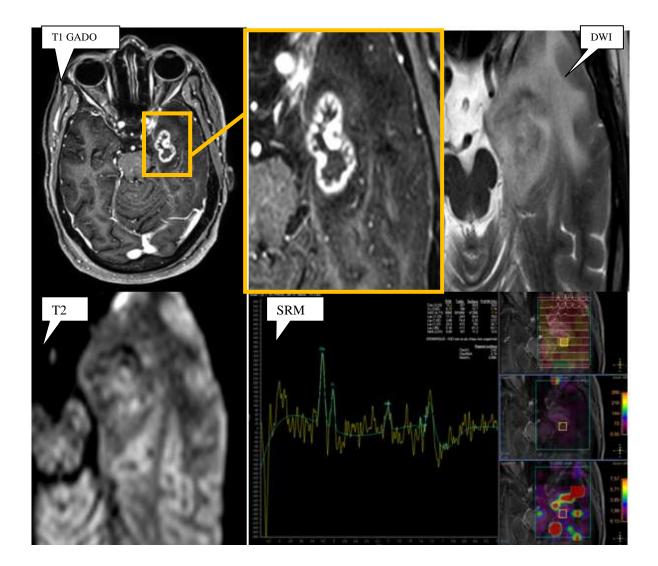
38 years old man finished radiation for his NPC, a year after he presented intense headache with several episode of convulsions . MRI showed a temporal lesion with peripheral enhancement with a slight internal restriction on DWI sequence and peripheral edema on T2. SRM is showed a inversion of the Cho/NAA ratio and a slight increase of lip
